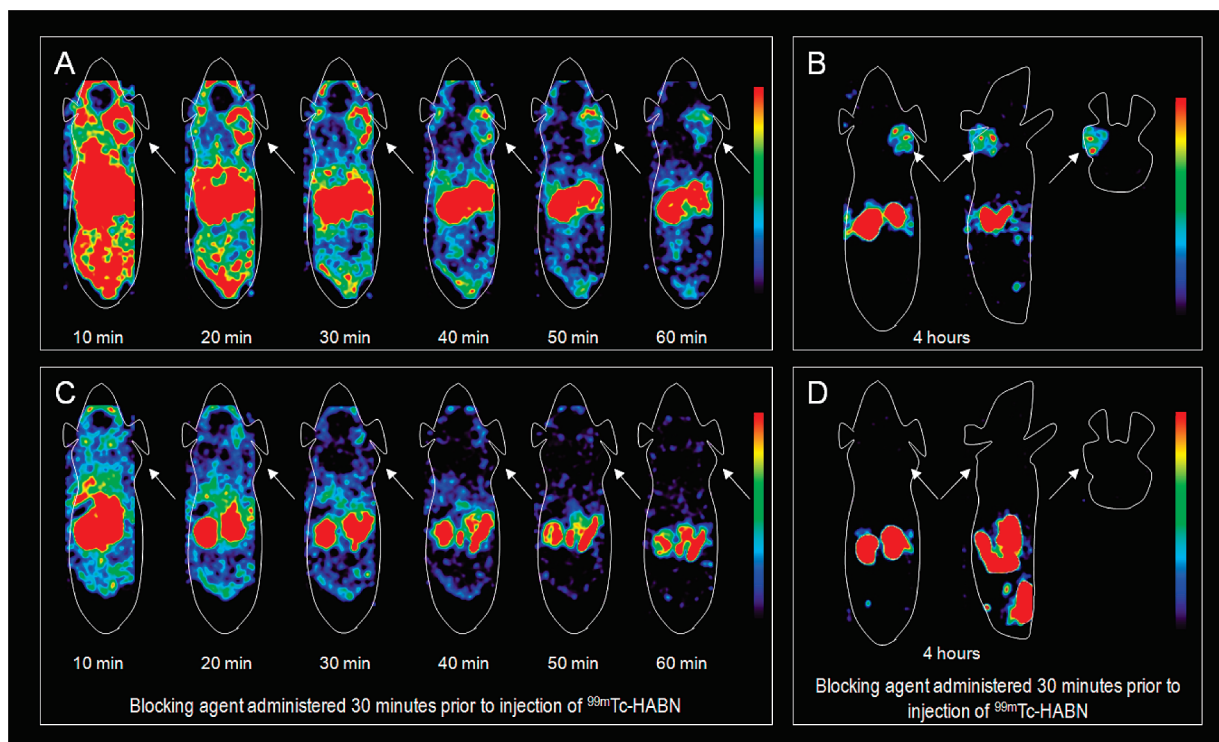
Coronal microSPECT images (sections) at ten minute intervals during the first hour after injection of ^{99m}Tc -HABN without blocking agent (A) and with blocking agent (C). Static coronal, sagittal and axial images (sections) 4 h after injection of ^{99m}Tc -HABN without blocking agent (B) and with blocking agent (D). Arrows indicate the tumor.
